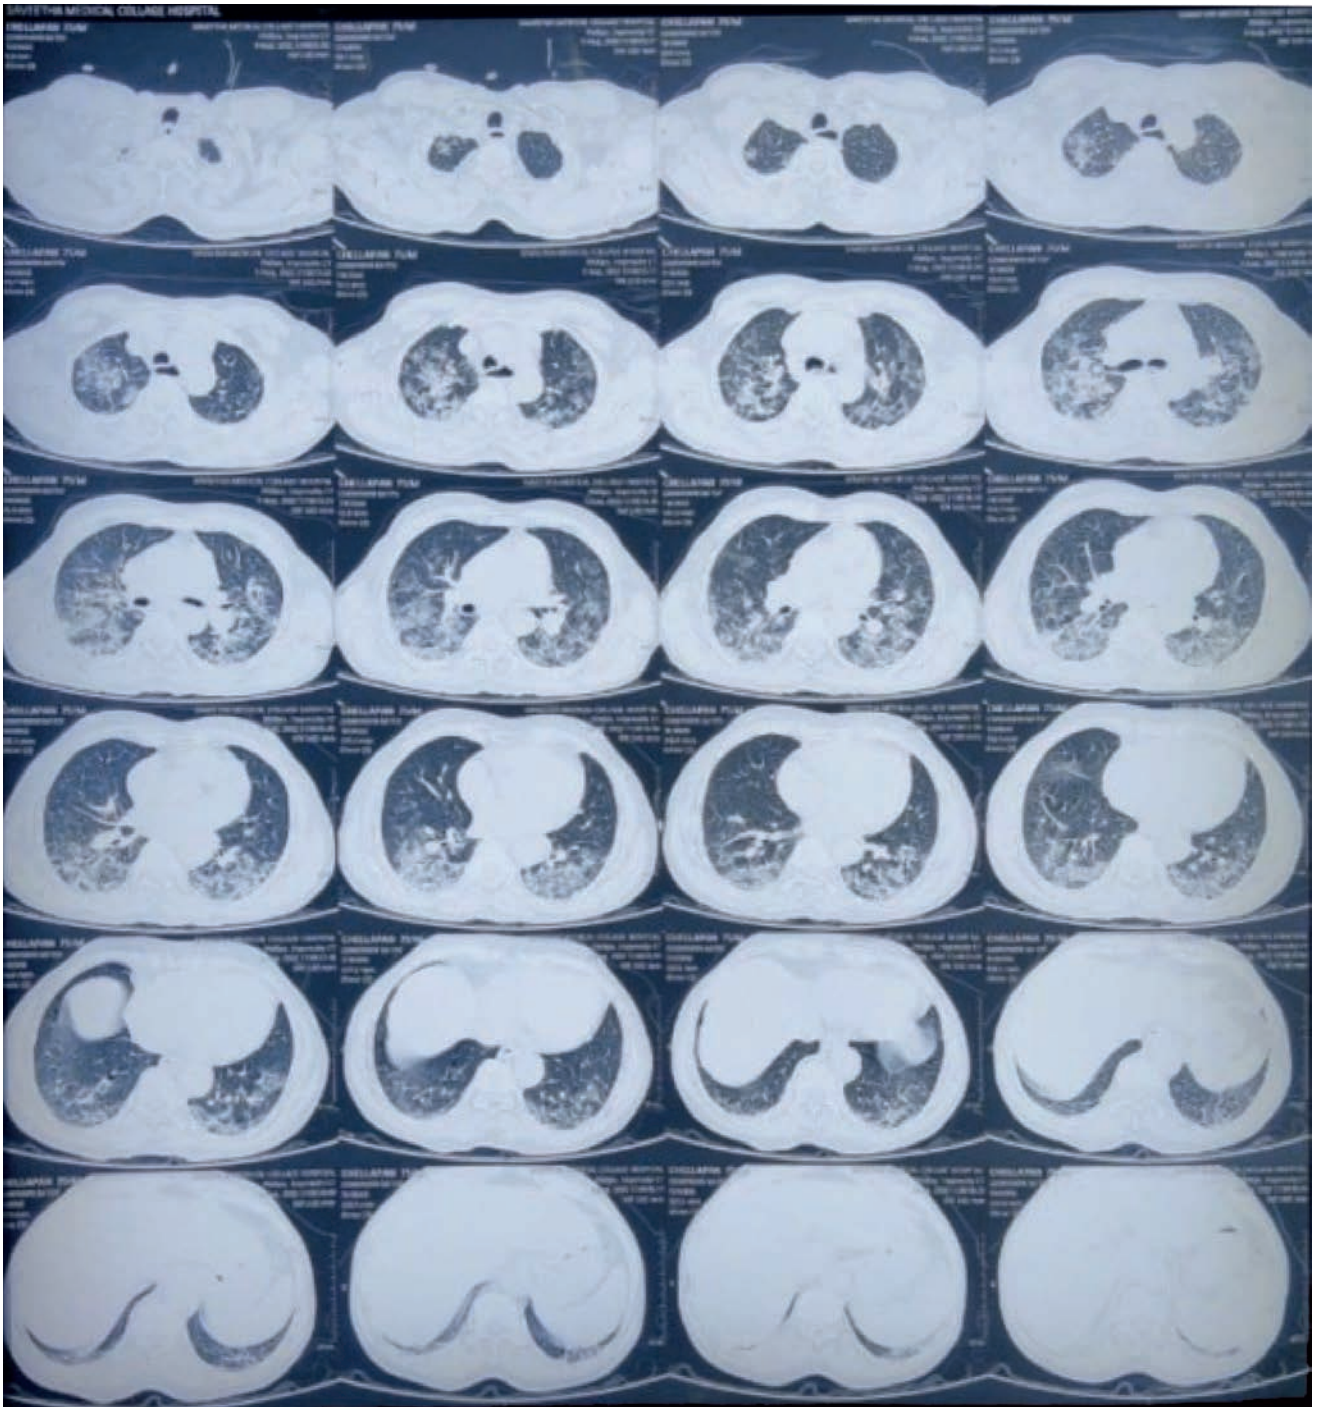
HRCT THORAX - Diffuse ground glass opacities with interlobar septal thickening giving crazy paving appearance noted in upper and lower lobes of both lungs
